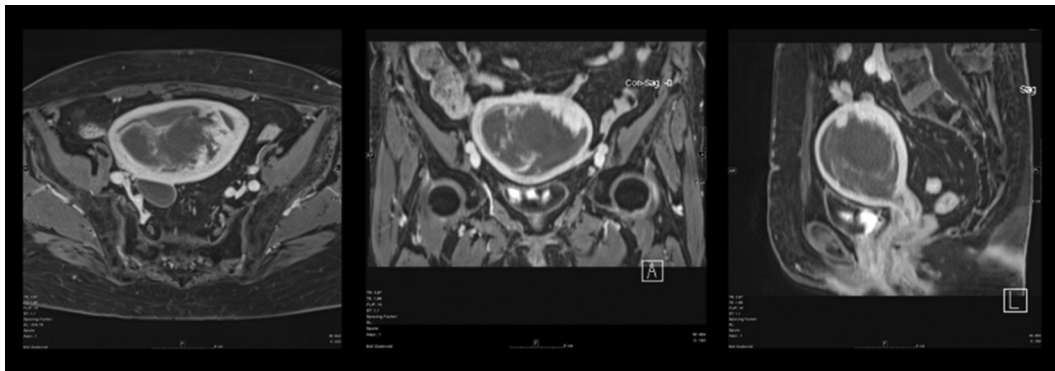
Diagnostic MRI previous to operation in case 1. T1-weighted MRI image with contrast (6 ml Gardovist intravenously), (A) axial, (B) coronar, (C) sagittal position.
